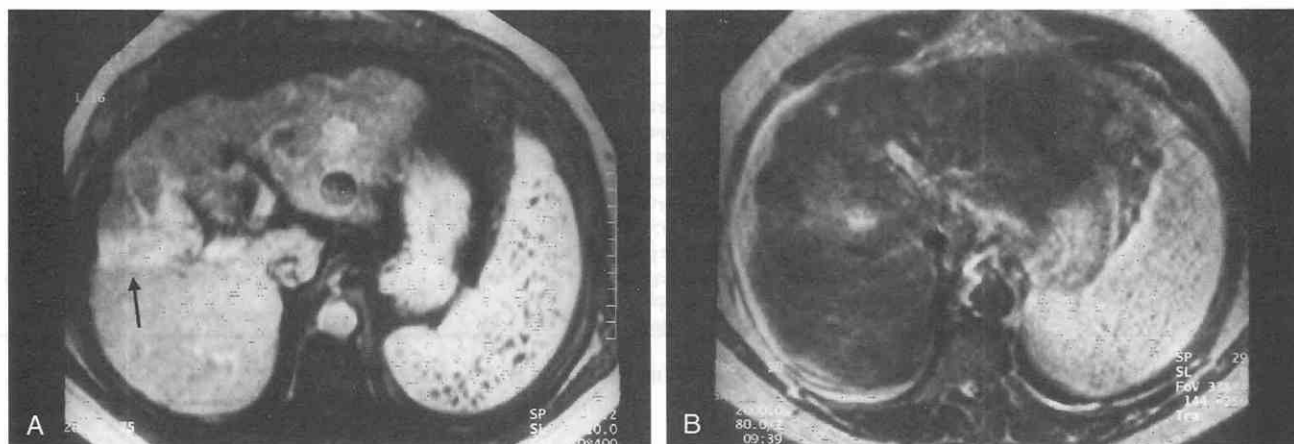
MR images showing multiple gamma-gandy bodies. A, T1-weighted image demonstrates multiple low-signal foci in the spleen consistent with gamma-gandy bodies. There is also an enhancing hepatocellular carcinoma in the liver (arrow). B, T2-weighted image reveals the low-signal splenic gamma-gandy bodies.
